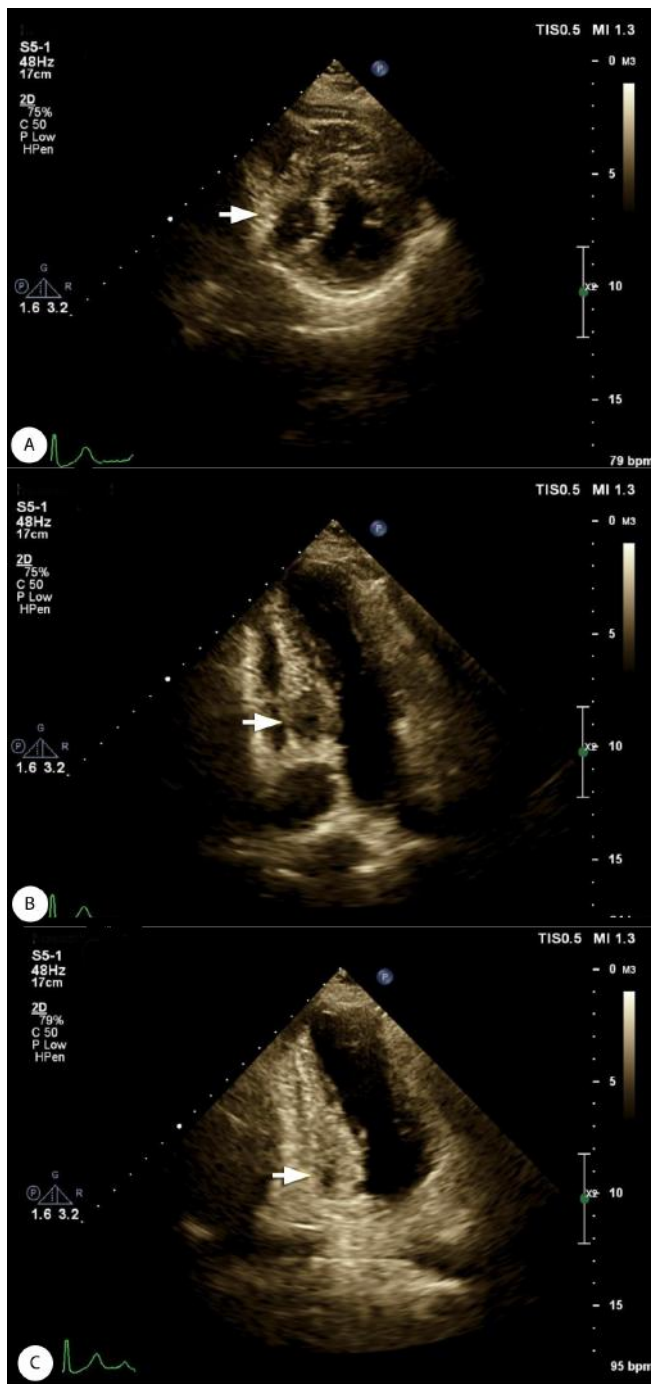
Transthoracic echocardiography shows an intramyocardial mass with an echo-free center (arrow) in the base-to-mid portion of the inferior and inferoseptal walls.
